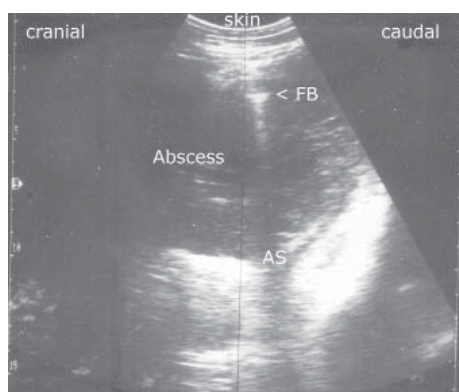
Longitudinal sonogram of the swelling in Fig. 1. It appears as a circumscribed structure containing hypoechoic fluid representing an abscess. The foreign body is hyperechoic and produces an acoustic shadow. Percutaneous exploration confirmed the diagnosis. FB = foreign body, AS = acoustic shadow.
